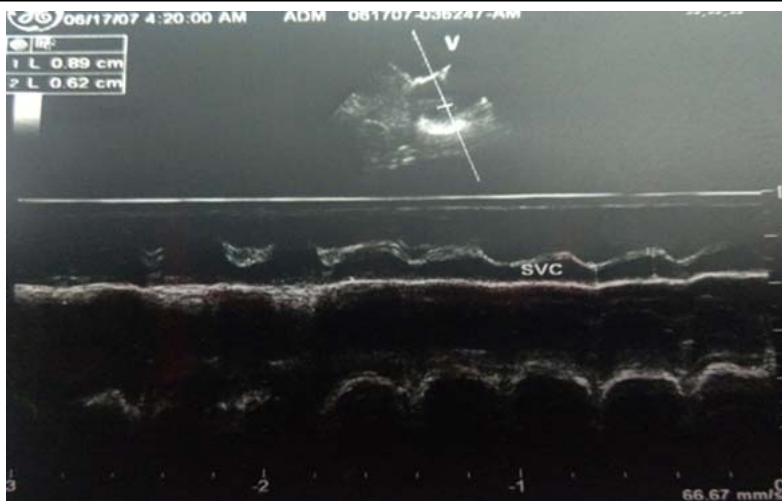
Showing M mode echocardiography of measuring SVC diameter in healthy preterm neonate.
